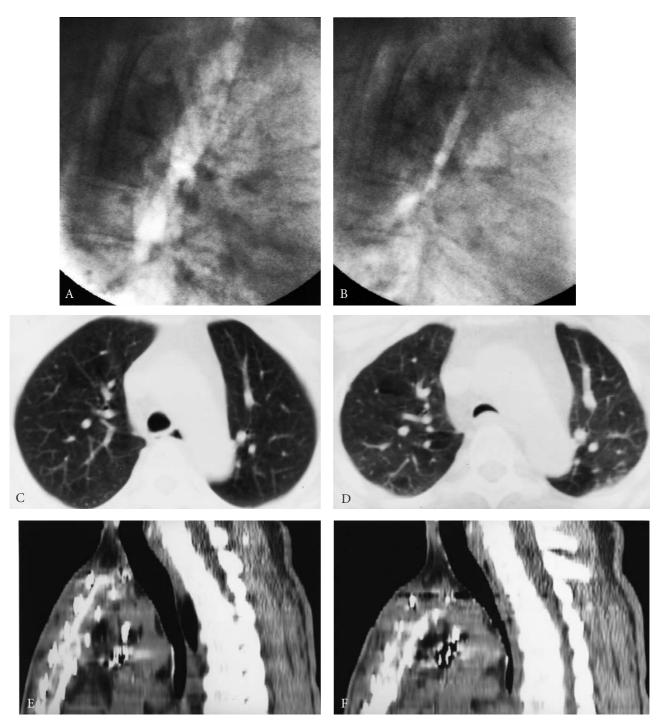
Tracheomalacia. Lateral fluoroscopic images of the trachea during inspiration (A) and expiration (B), computed tomography (CT) of the midtrachea on inspiration (C) and expiration (D), and two-dimensional reformatted sagittal CT images of the trachea on inspiration (E) and expiration (F) demonstrate > 50% collapse in the anteroposterior diameter of the trachea, consistent with tracheomalacia.
